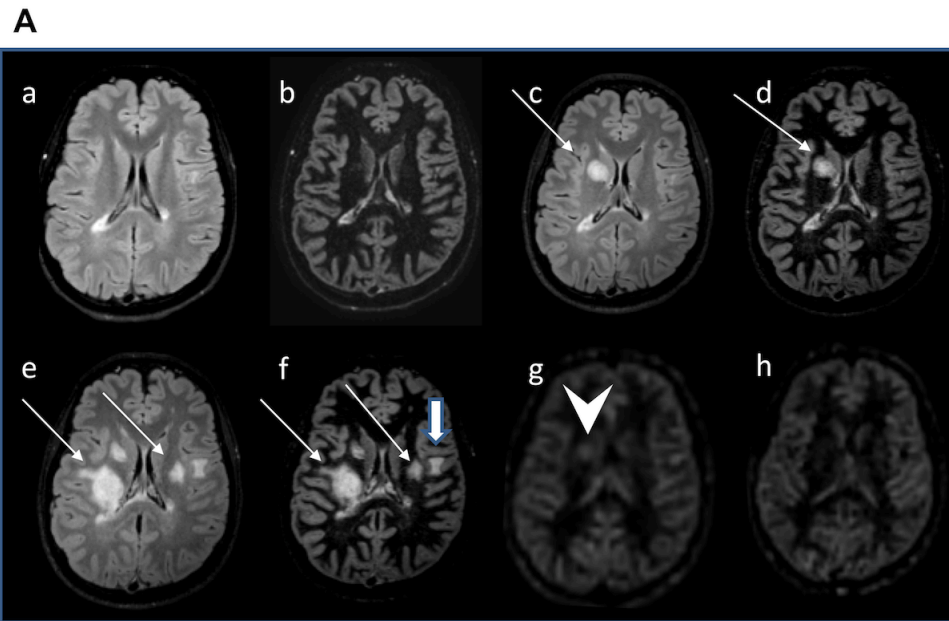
A: Male patient 25 years old. Disease onset in February 2015. FLAIR and DIR sequence obtained at diagnosis (a and b), in 2017 (c and d) and in 2018 (e and f). The significant increase of the lesion load in the white matter (thin arrows) and in the gray matter (thick arrow) parallels several severe clinical relapses with the appearance of a severe left hemiparesis. Perfusion sequence showed increased perfusion in one of the lesions, adjacent to the head of the R caudate nucleus (arrowhead); this hyperperfused lesion disappeared at the following MRI control (h).
